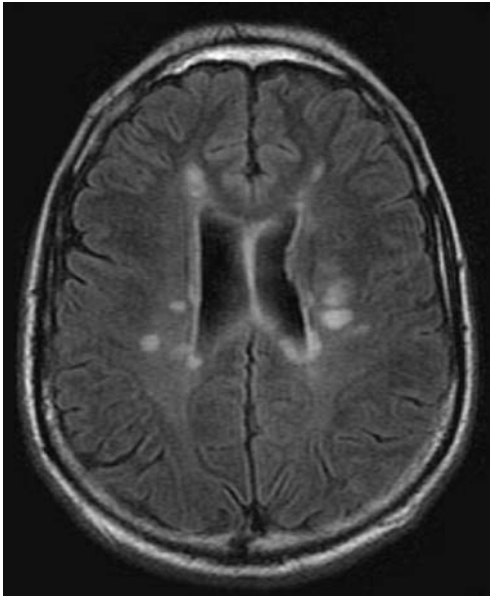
Axial brain MRI (FLAIR sequence) demonstrating hypersignals in the periventricular white matter
